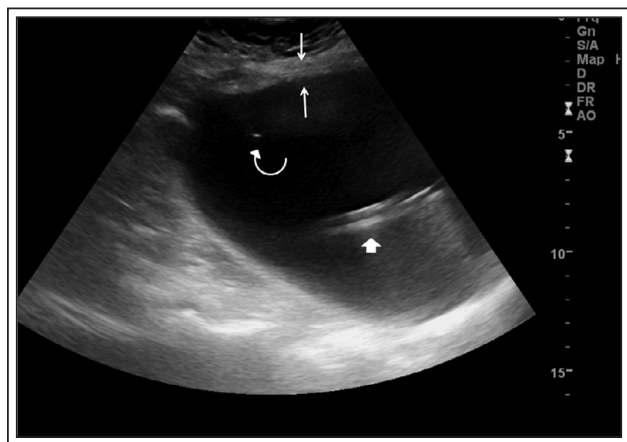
Ultrasound image (sagittal) of distended bladder (anterior bladder wall identified between straight arrows) without intervening bowel. A cystoscope (wide arrow) is identified within the bladder lumen. An introducer needle tip (curved arrow) is identified within the lumen of the bladder.
